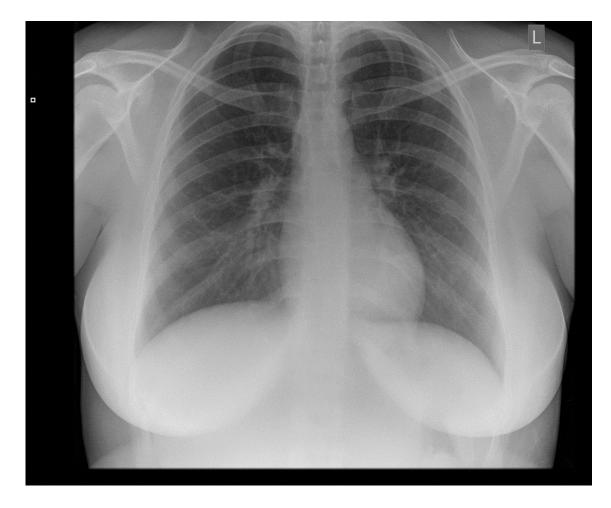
Normal chest X-ray (CXR) of a 23-year-old female in posteroanterior (PA) view [134].
